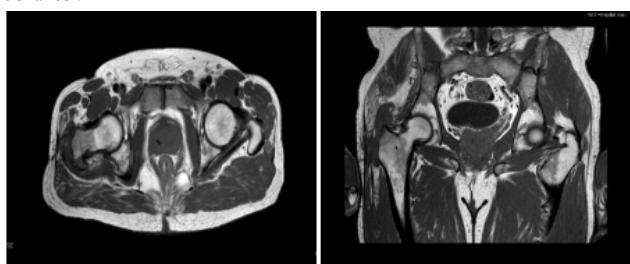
& 3 Axial and coronal MRI image: Intraosseous edema of the right greater trochanter, inflammatory phenomena of the soft tissues.
